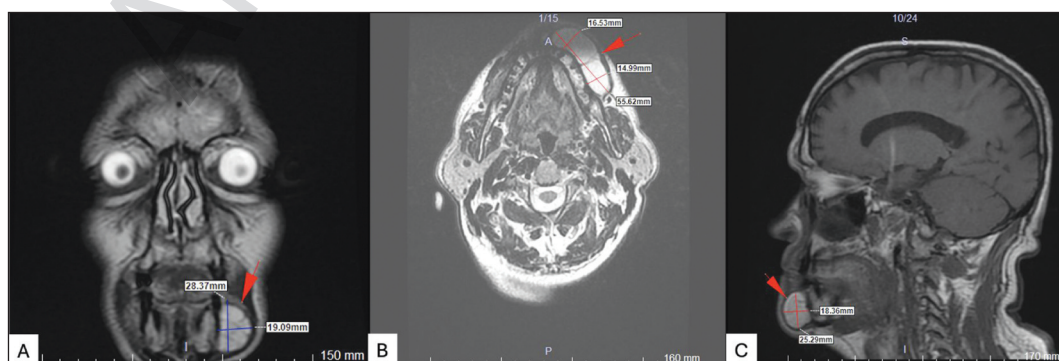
Magnetic resonance imaging; A) Frontal section; B) Axial section; C) Sagittal section
